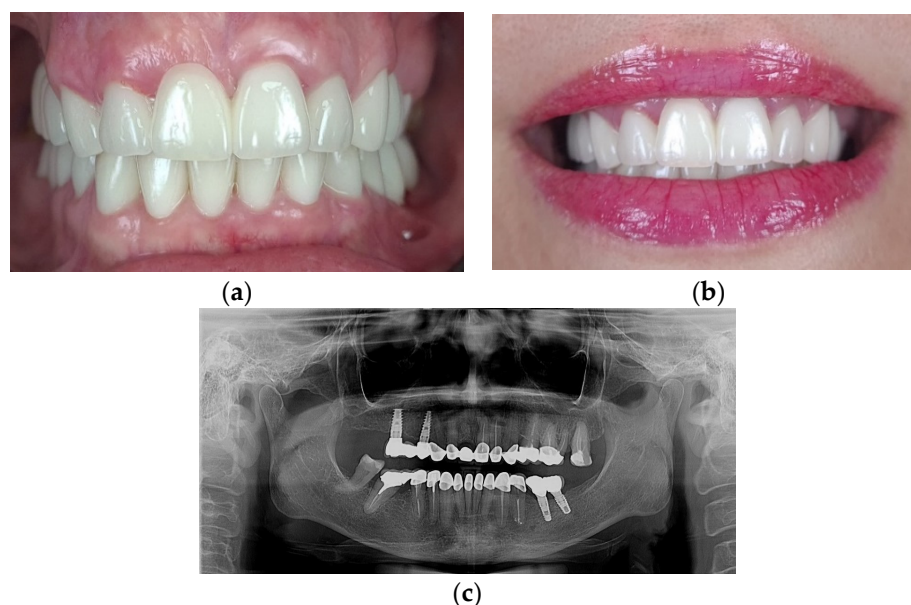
The final result of the full-mouth rehabilitation: (a) Intraoral aspect of the restorations; (b) The improved smile with minimal gingival display; (c) Panoramic X-ray after one year.
